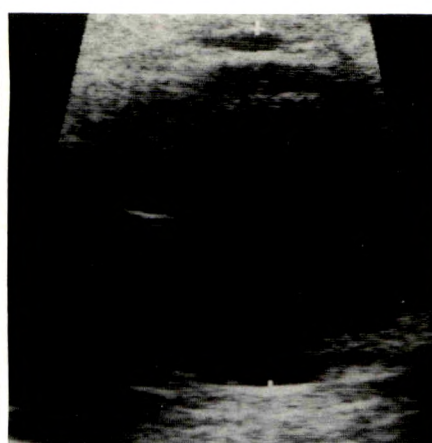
Intraocular lens implantation is almost always performed after cataract extraction. Sonogram shows characteristic reverberation artifact behind iris plane (arrow).
